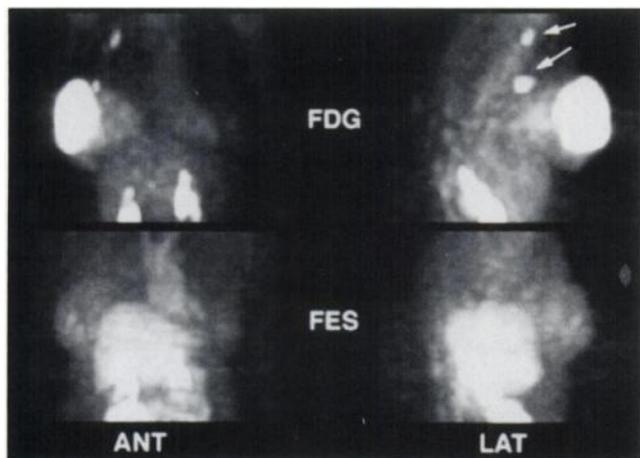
Anterior and right lateral volume-rendered maximum-activity-reprojection FDG and FES images from a patient with locally advanced breast cancer demonstrate discordant localization of both tracers in this ER-negative tumor. There is FDG uptake in the primary fungating right breast mass (8.0 cm diameter) and in right axillary nodal metastases (arrows) but no FES uptake in either site.
